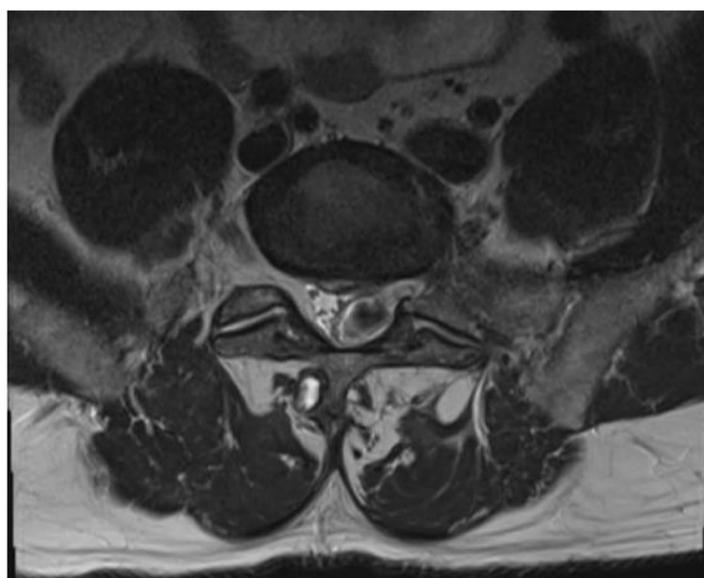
Sagittal (A) and Axial (B) T2 weighted MRI images for Case 1 with demonstration of L4-5 hemorragic synovial cysts and nerve root compression as well as grade I spondylosthesis.
